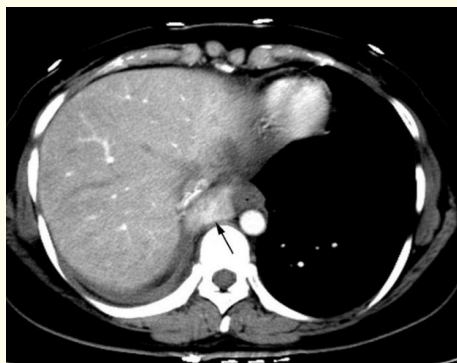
Follow-up CT at postoperative 12 months showed residual mass and stable lesion in the inferior vena cava.
